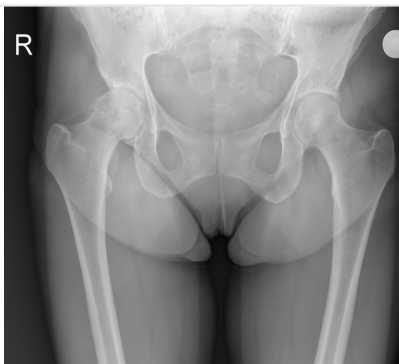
Postoperative X-ray of the same patient with pincer type impingement and Tönnis grade 2 arthrosis
